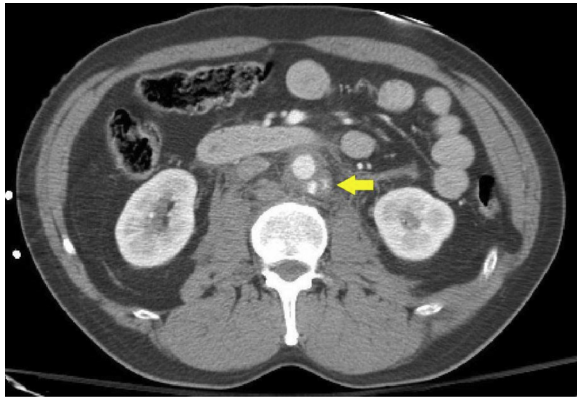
Computed tomography (CT) scan of infrarenal aorta with pseudoaneurysm. The *arrow* denotes pseudoaneurysm.
